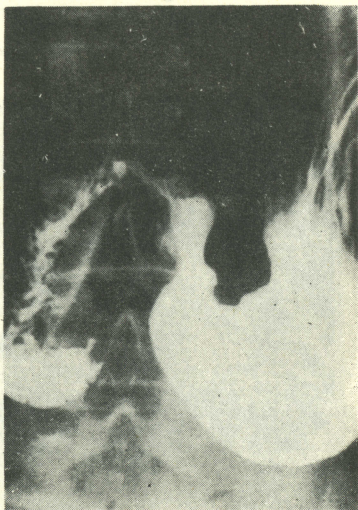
X-ray of case No. 11 shows an irregularity of the Antrum, L.C., and widening of the Angle.
